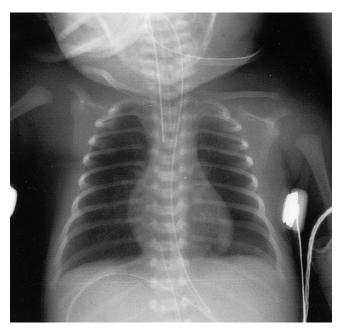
Anteroposterior chest radiograph: No evidence for pneumothorax or pneumopericardium. An area of hyperlucency is noted behind/within the left cardiac border.
